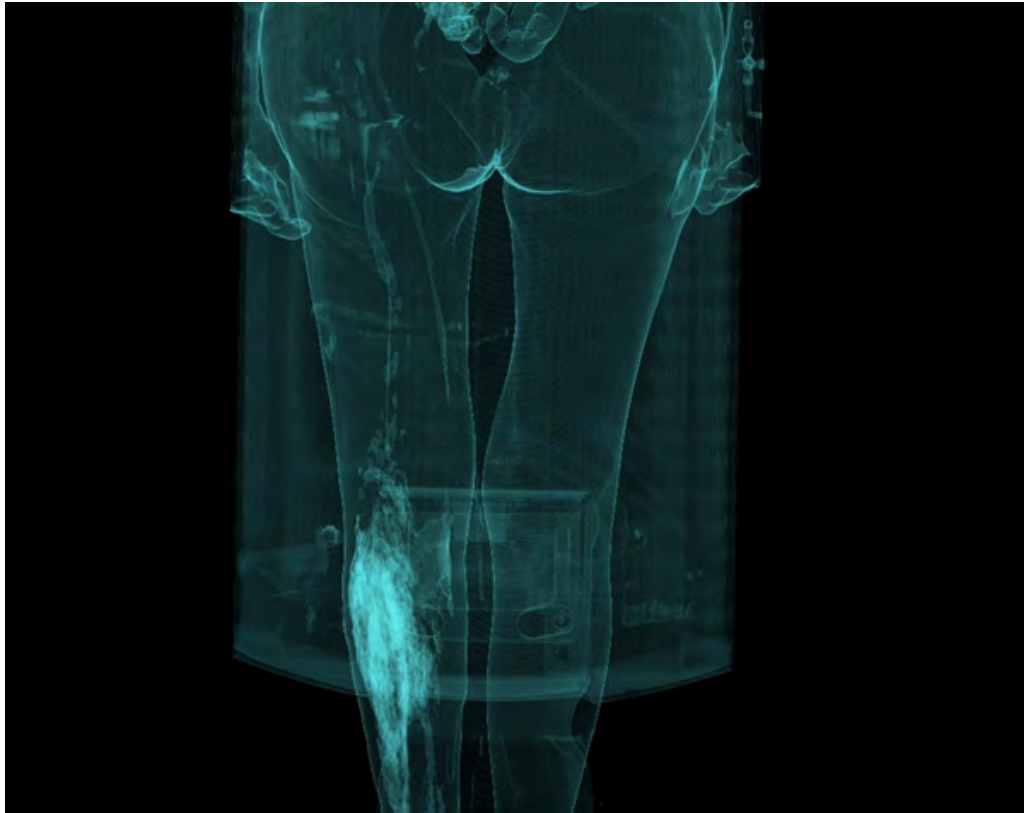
Computed tomographic reconstruction showing gas collection in fascial planes and subcutaneous tissues
